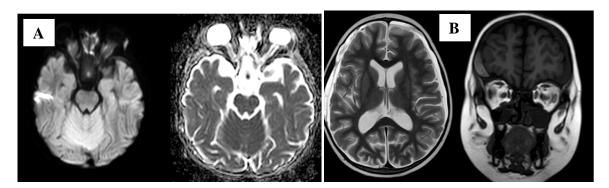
Magnetic resonant imaging (MRI) brain of case 2. A: There is diffuse thickening of the optic nerves sheathes bilaterally with related DW restriction with signal alteration of both optic nerves and flattening of both optic discs. B: Mild right parietal localized subdural collection with iso to high signal intensity on T2 and FLAIR and low signal intensity on T1W1 suggestive of subacute subdural hematoma
